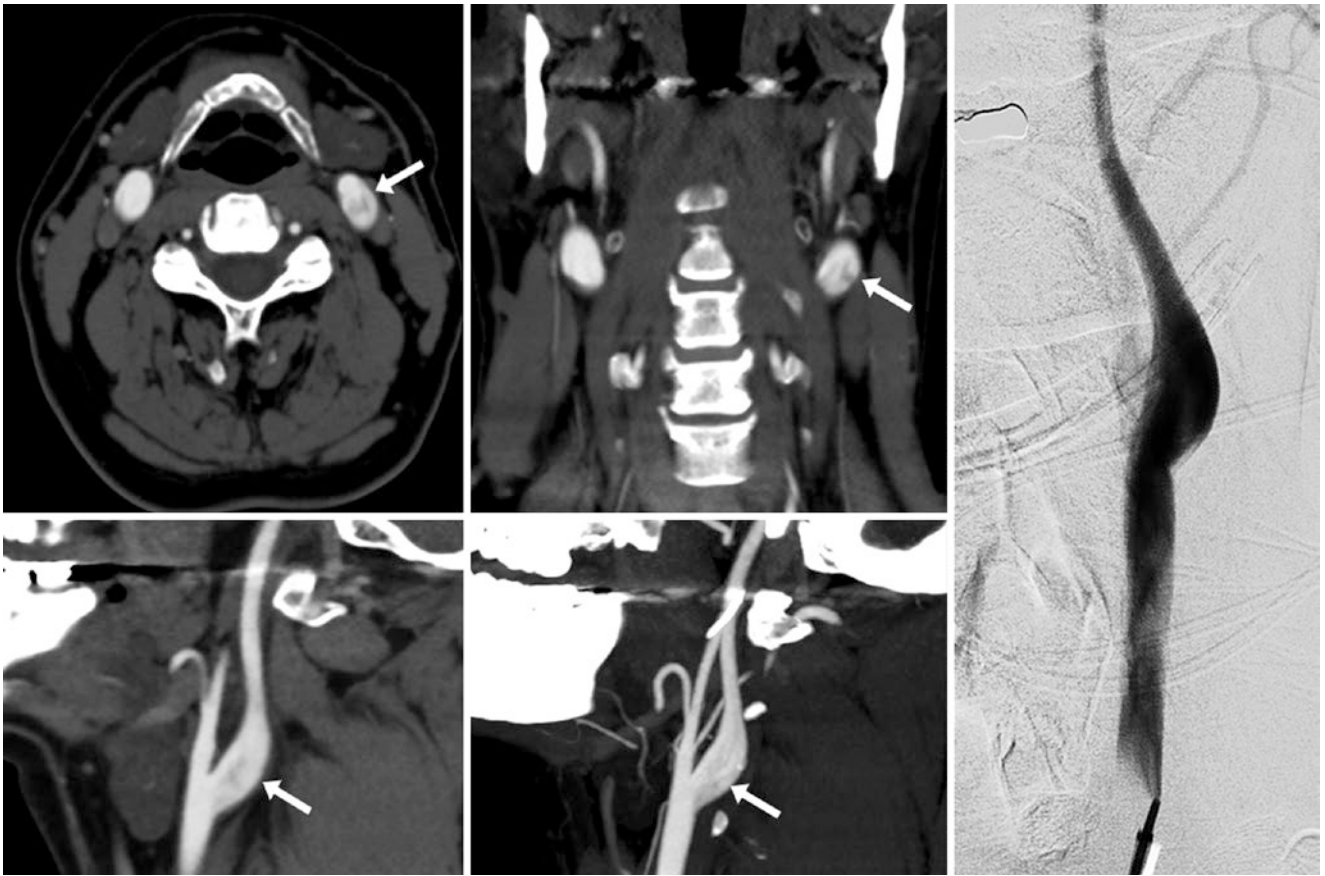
53-year-old with trauma and pseudodissection. The pseudodissection artifact (*arrows*) is located at the left ICA origin on axial (*left*) and coronal (*middle*) MPRs from a 128-slice CTA. An intimal flap was initially suspected (*arrows*). A subsequent catheter DSA (*right*)
